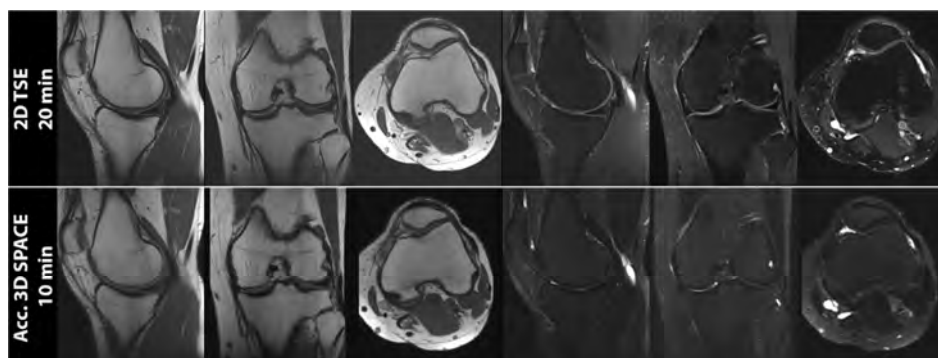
Comprehensive high-spatial resolution MRI protocol of the knee in a 44 year old man. The top row shows sagittal, coronal, and axial intermediate-weighted and fat saturated T2-weighted 2D TSE images. The bottom row shows sagittal, coronal, and axial reconstructions from intermediate-weighted and fat saturated T2-weighted 3D SPACE sequences with acceleration of acquisition times through k-space undersampling and iterative reconstruction. The total acquisition time of the 2D and 3D protocol is given.
